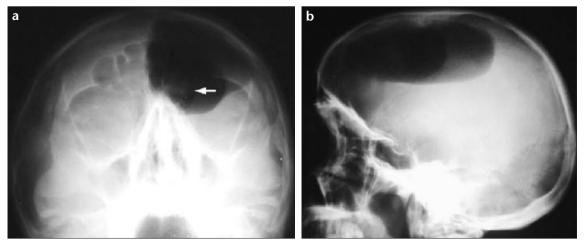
a, b. Occipitomental radiograph (a) shows intracranial air collection in the left frontal region and a subtle osseous lesion in the left frontal sinus (arrow). Lateral radiograph of the skull (b) confirms that the air collection is located intracranially.
